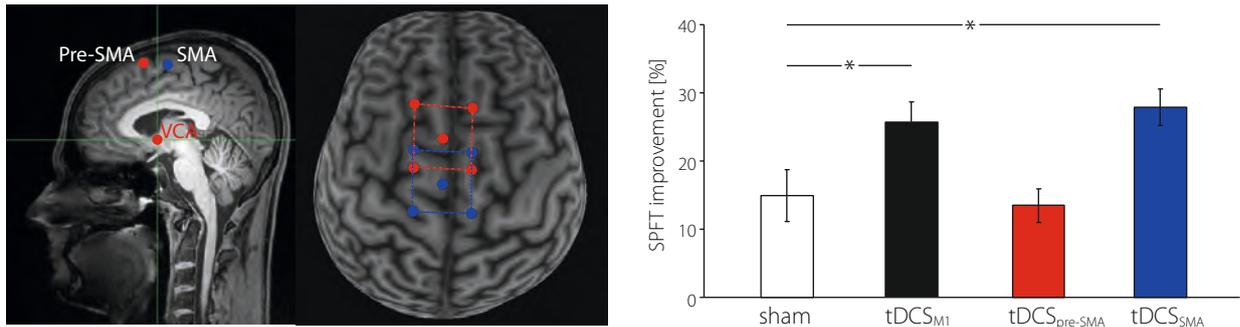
Upper figure: Target coordinates for left pre-SMA (MNI: $-3, 18, 57$) and SMA proper ($-3, -2, 57$) in the sagittal view of a representative subject's T1-weighted MRI scan. Please note that both target coordinates show the same distance to the vertical commissure anterior line (VCA). Target regions for SMA/pre-SMA projected on a 3D reconstruction for one representative subject. The rectangles represent the electrode placement of the active anodal tDCS electrode around the target coordinate, blue for the SMA and red for the pre-SMA condition. In all conditions, the cathode was positioned over the forehead. Lower figure: Sequence-specific learning of the right hand (expressed as sequence learning minus random learning in percent of baseline performance) in the SPFT. Subjects receiving anodal tDCS over SMA or M1 showed an enhanced visuomotor learning as compared to subjects receiving anodal tDCS over pre-SMA or sham.
